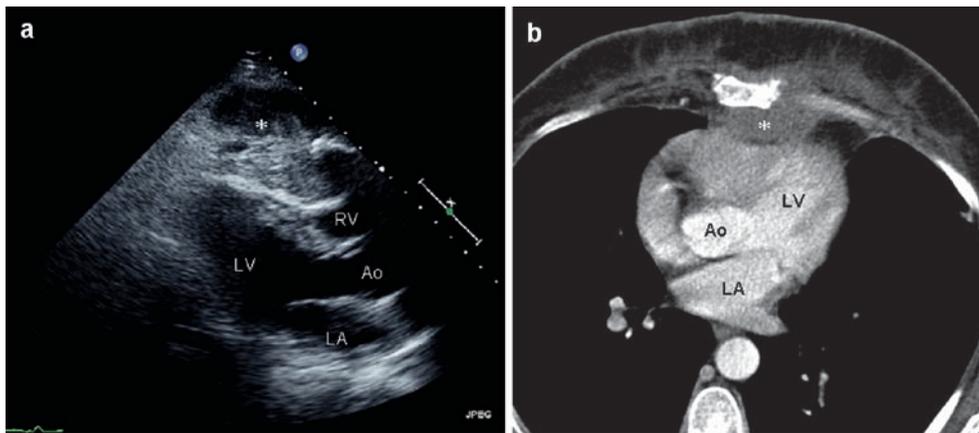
Sternal metastasis of breast carcinoma in a 47-year-old female patient with marked displacement of the heart and compression of right heart chambers. Trans-thoracic echocardiographic imaging in a parasternal view (a) shows an isodense tumour mass of heterogeneous appearance (asterisk) with infiltrative growth into
